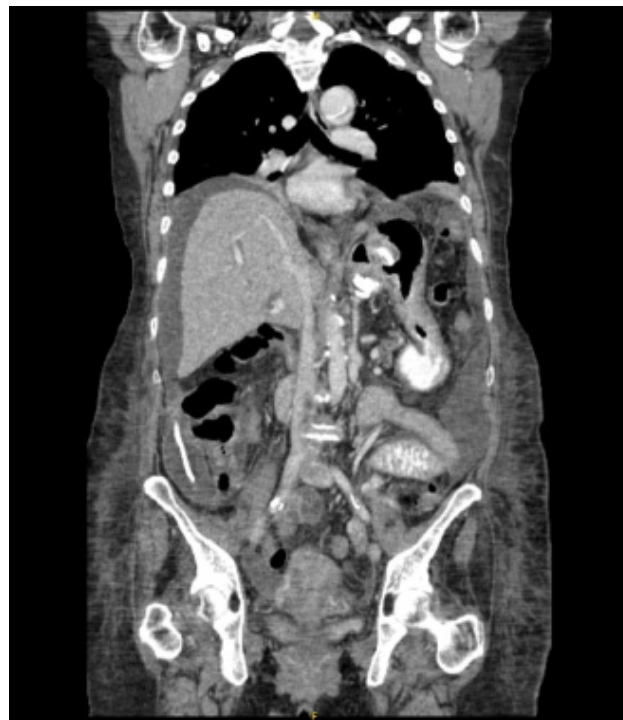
Sagittal CT scan demonstrating band extending the free-floating tubing draping toward the ascending colon.
